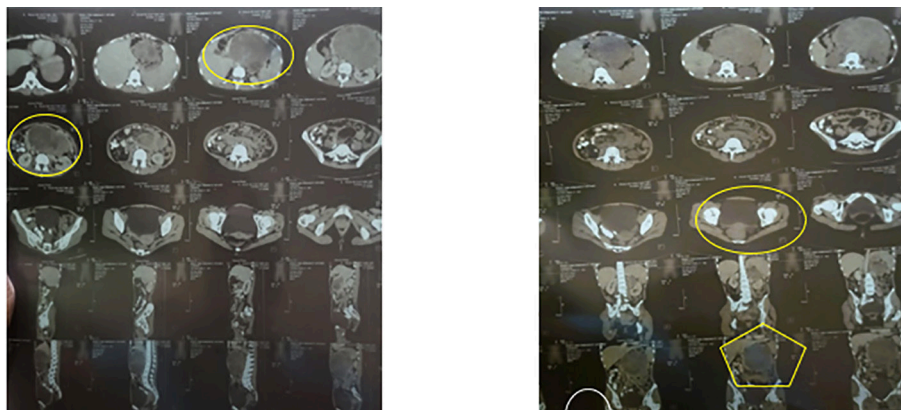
CT scan abdomen shows an enlargement mass from the pancreas compressed superiorly to gaster, well-margined, encapsulated, solid and cystic mass.
